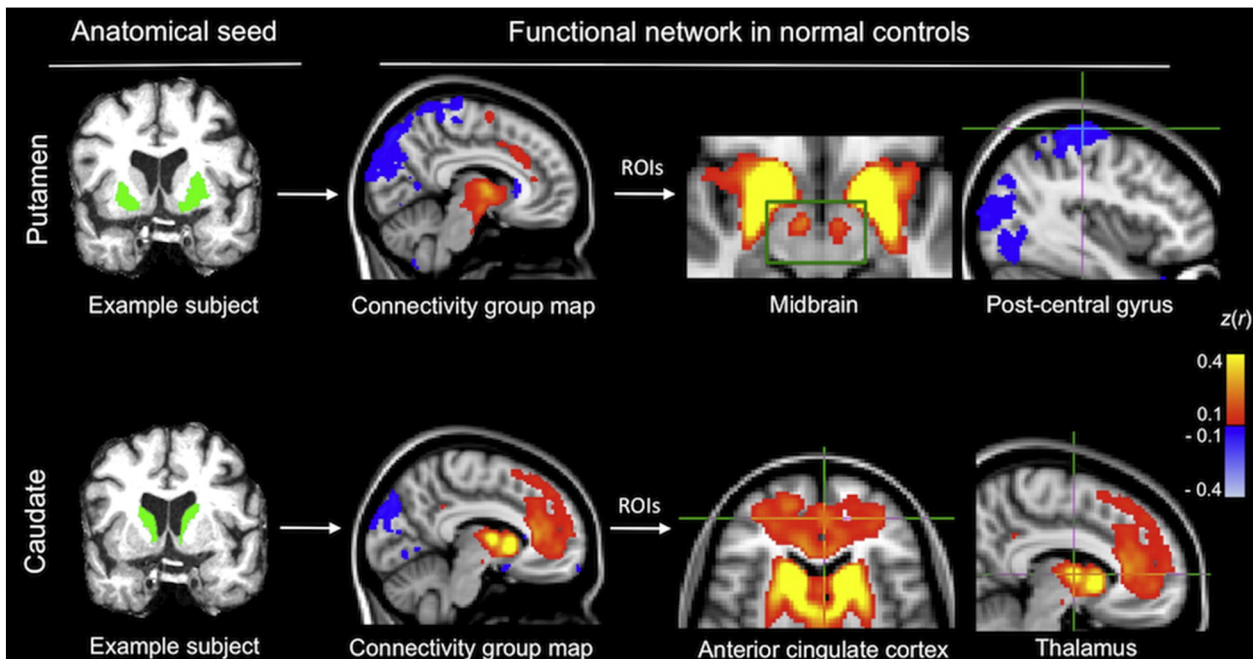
Putamen and caudate seeds were defined based on anatomy from the individual subject structural MRI. Example putamen and caudate ROIs for one subject are shown. Whole-brain functional connectivity MRI maps using the putamen and caudate as seed region were then calculated in 29 clinically normal older adults to define regions of interest for further analyses in the patients. ROIs were identified as peak connectivity estimates of known regions within the caudate and putamen networks (Di Martino et al., 2008; Hacker et al., 2012). For the putamen network we selected peaks in the right and left midbrain (MNI coordinates right $x = 10$, $y = -8$, $z = -12$, left $x = -8$, $y = -10$, $z = -12$) and right and left postcentral gyrus (MNI coordinates right $x = 36$, $y = -26$, $z = 68$, left $x = -34$, $y = -20$, $z = 68$). For the caudate network we included peaks in the anterior cingulate cortex (MNI coordinates $x = -2$, $y = 46$, $z = 6$) and right and left anterior thalamus (MNI coordinates right $x = 10$, $y = -2$, $z = 6$, left $x = -10$, $y = -4$, $z = 8$).
